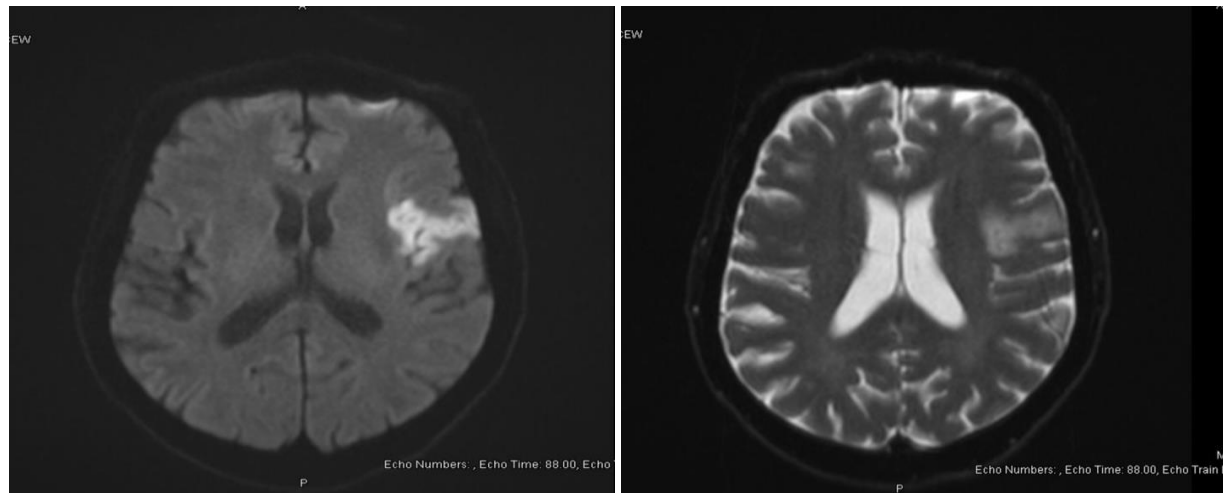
MRI brain showing small areas of acute infarcts within superior division M2 segment of left Middle Cerebral artery.
